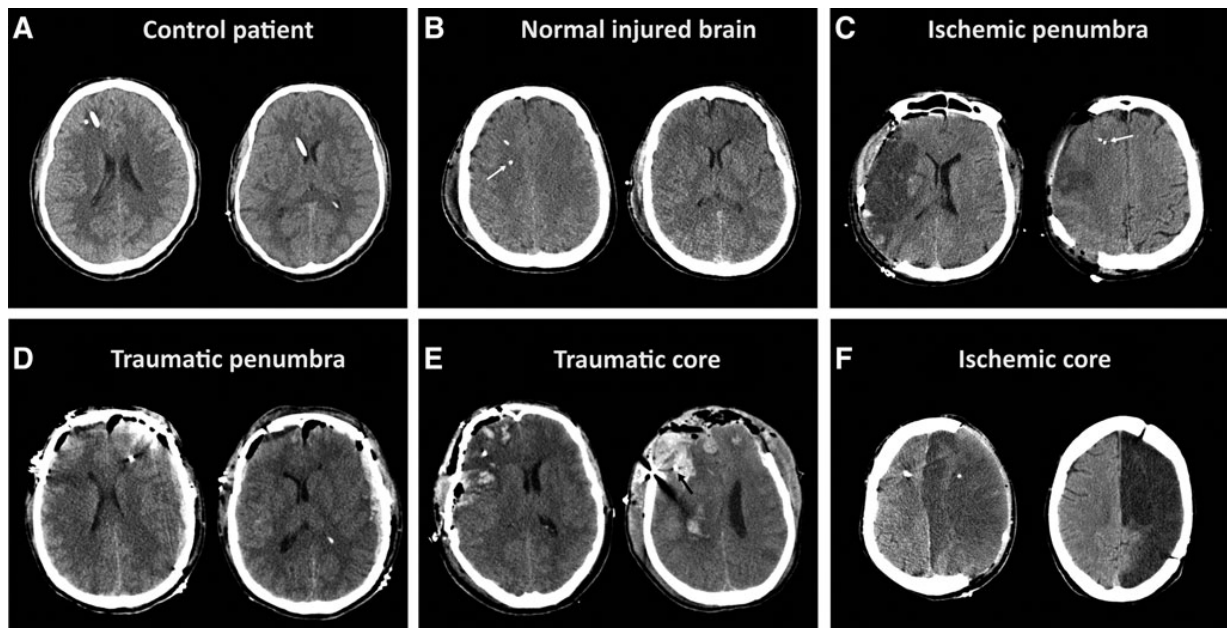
Examples of the different brain areas defined according to the placement of the cerebral microdialysis (CMD) catheter. For further explanation, see the Material and Methods section. (A) Control patient. A 34-year-old male operated on for a right giant vestibular schwannoma. The tip of the cerebral microdialysis probe is shown on the left of the ventricular catheter that is placed in the right frontal horn. (B) Normal injured brain. A 46-year-old male admitted to the neurocritical care unit after severe traumatic brain injury (TBI) with an admission Glasgow Coma Scale (GCS) score of 4. The patient was included in the diffuse injury II of the Marshall's classification. The control CT showed that both the CMD probe (arrow) and the brain tissue oxygen (PtiO₂) probe (anterior to the CMD probe) were inserted in the frontal subcortical white matter in a brain region without any observed gross abnormality. (C) Ischemic penumbra. A 46-year-old male admitted to our institution 5h after an abrupt onset of left hemiparesis. The National Institute of Health Stroke Scale (NIHSS) score on admission was 13. Because of the clinical and neuroradiological evolution to a malignant stroke, the patient underwent decompressive hemicraniectomy 32 h after the stroke onset. On the left CT scan, the infarction extension is seen with preservation of the anterior cerebral artery territory. On the right CT, the CMD catheter (arrow) is shown 27 mm from the hypodense lesion (ischemic core). (D) Traumatic penumbra. A 52-year-old male was injured in a blast. His GCS score on admission was 5. On admission, he was operated on for a left-acute subdural hematoma, left frontal contusion, and right extradural hematoma. A CMD probe was inserted at the end of surgery in the left frontal lobe (left CT scan). (E) Traumatic core. A 48-year-old male was admitted because he had sustained a brain injury in his workplace. His GCS score on admission was 7. He was immediately operated on for evacuation of right hemorrhagic contusion and a bifrontal extradural hematoma. A bifrontal decompressive craniectomy was also performed. In the control CT, the PtiO₂ probe is seen on the left, and the CMD is visible on the right slice (arrow). Some metallic artifacts are generated by an eight electrode electrocorticography strip placed on the right frontal lobe. (F) Ischemic core. A 52-year-old male who underwent decompressive hemicraniectomy because of a malignant stroke 14 h after stroke onset. The control CT showed the CMD probe inserted in a large area of hypoattenuation corresponding to the core of the infarction. The control CT scan of the same patient 1 year after surgery (right) shows the residual hypodense necrotic brain.
